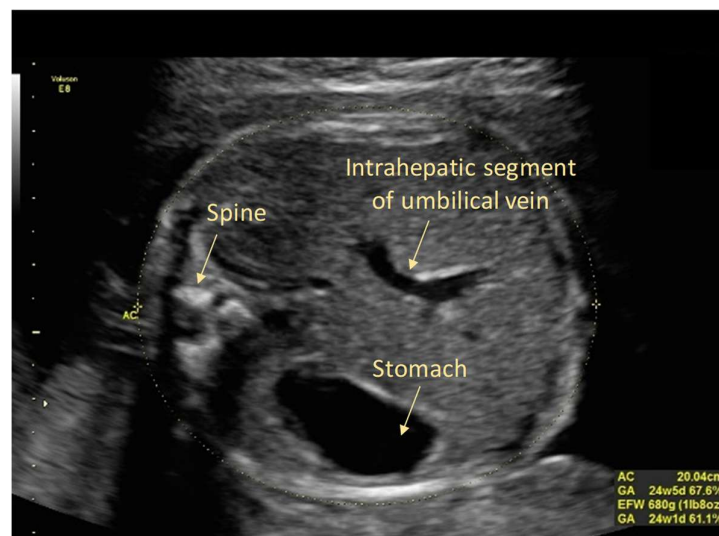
Fetal abdomen imaged with contemporary ultrasound equipment at the measurement plane for the abdominal circumference. Note electronic 'on-screen' callipers and measurements displayed (bottom right corner) with equivalent gestational age and centiles for known gestational age. Image produced by D Paoletti.
